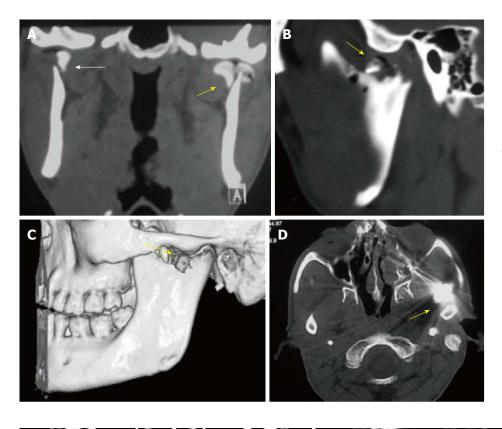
Condylar fractures in different patients. Coronal (A), sagittal (B) and 3D (C) reconstructed CT images depict bilateral displaced, extracapsular (right-bold arrow), and intracapsular (left- arrow) condylar head fractures with involvement of the articular surface on the left side. The intra-articular air on the left side indicates an open wound (arrow). Open joint wound with a foreign body (bullet in another patient- D) or gross contamination are indications for open surgery.
